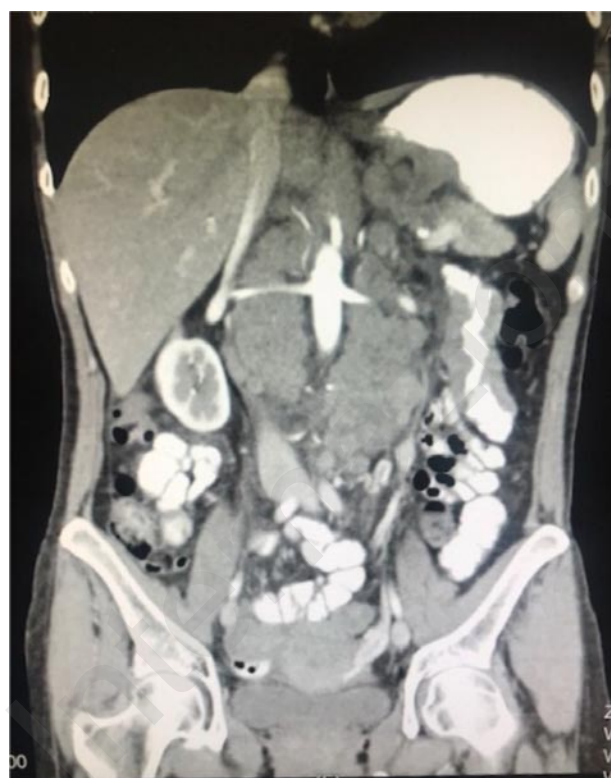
Computed tomography scan showing severe retroperitoneal lymphadenopathy.
